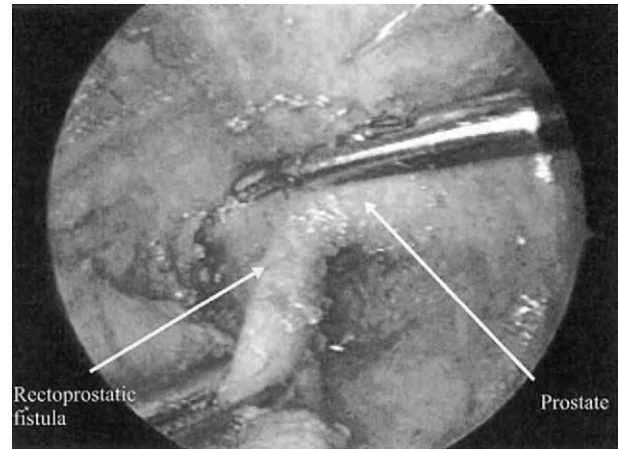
The completed dissection of the rectoprostatic fistula before division is shown. The upper instrument is pushing up on the prostate and bladder, and the lower instrument is grasping the rectum. (From Sydorak RM, Albanese CT: Laparoscopic repair of high imperforate anus. *Semin Pediatr Surg* 11:217-225, 2002.)
